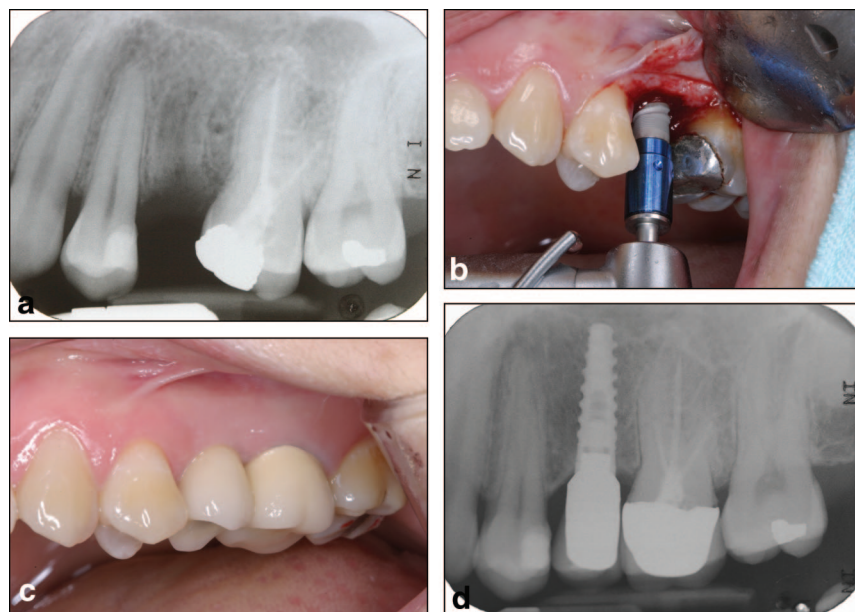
a, Initial periapical radiograph. b, Implant placement using handpiece. c, The final prosthesis was fabricated with the porcelain-fused to metal crown. d, Periapical radiograph taken 12 months after loading.
